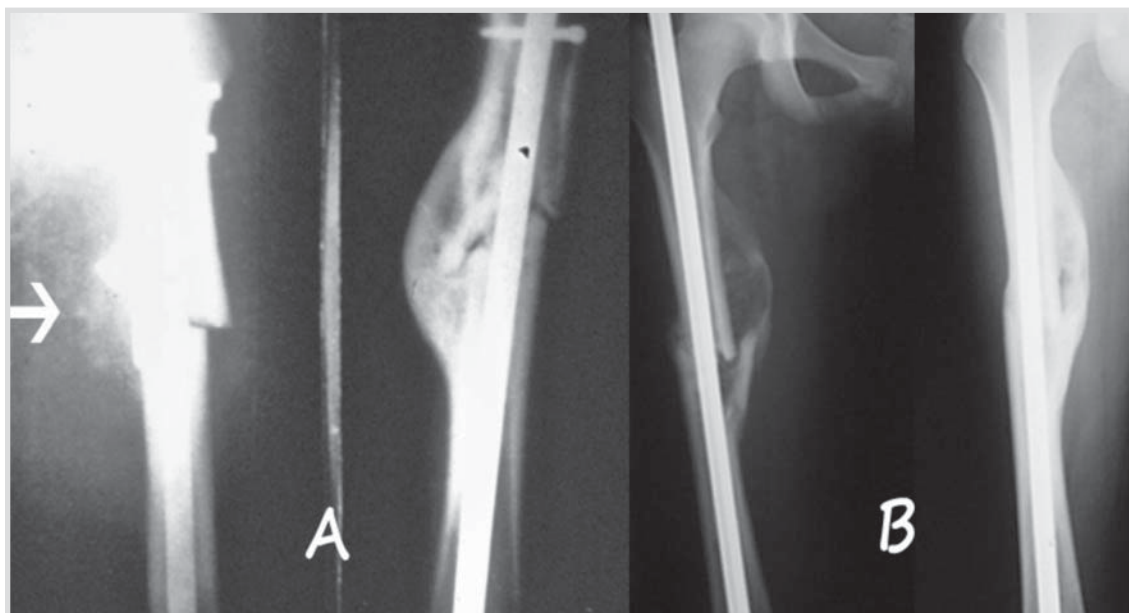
(a) Periosteal callus after closed fixation of femoral shaft fractures of the intramedullary nail. Cloud of forming callus in the early postoperative period (arrow). Another radiograph shows a consolidated after several months of periosteal callus, but without closing the gaps fracture. (b) Comminuted fracture of the femoral shaft fixed with Kuntscher's nail. The early step of forming periosteal callus on the medial side of the shaft and its good consolidation of them, several months after the operation
